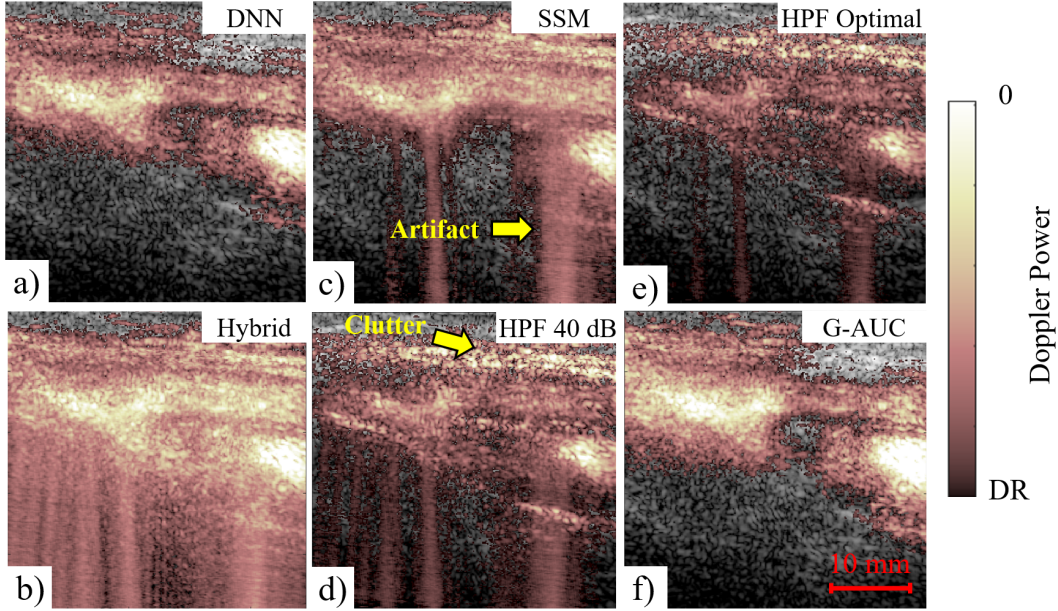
Power Doppler image of the femoral bifurcation and vein just after systole. Significant tissue motion is present and the flow signal is relatively weak (Frame 215). *a)* The proposed DNN SVD clutter filter, *b)* Hybrid method, *c)* SMM correlation method, and *d)* and *e)* high-pass FIR filter. Panes *a)* - *c)* are presented under 20 dB dynamic range. Pane *d)* is presented under 40 dB dynamic range. Pane *e)* has been rescaled to a DR of 42.6 dB DR relative to the maximum pixel intensity. *f)* ground AUC values (G-AUC) The proposed filter removes the majority of the surrounding clutter while maintaining good sensitivity to flow. Flow detection in the lower branch is generally poor for all filters.
